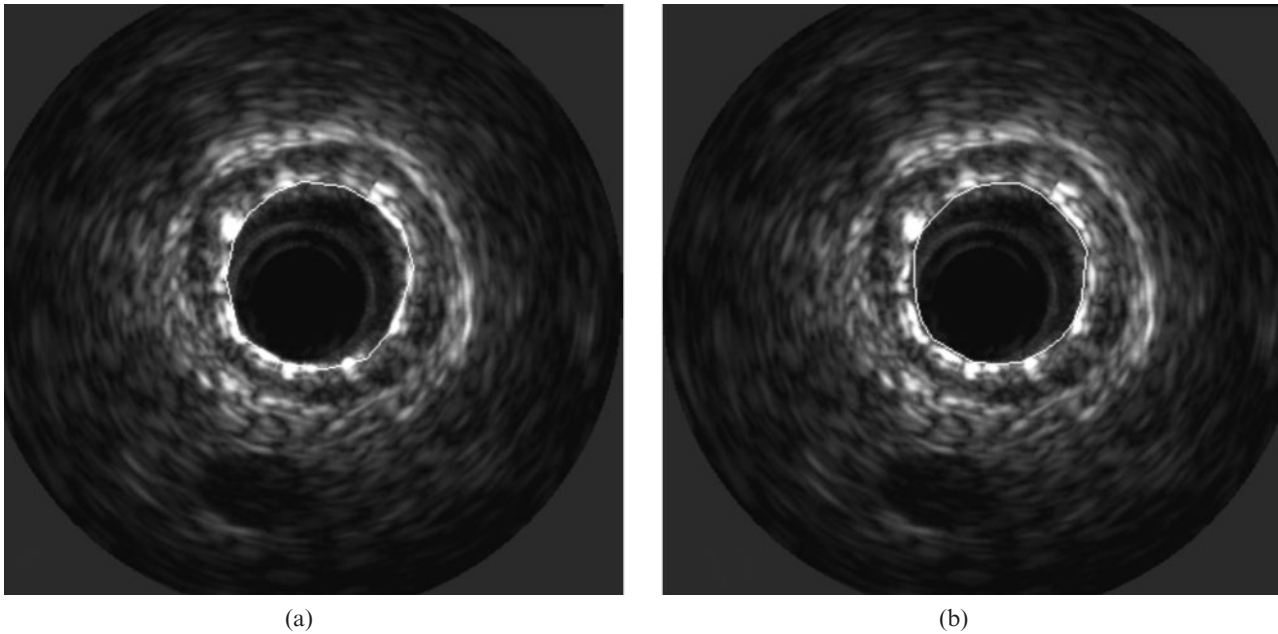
Stent border detection in an intravascular ultrasound frame by (a) an expert observer and by (b) our automated segmentation method.
